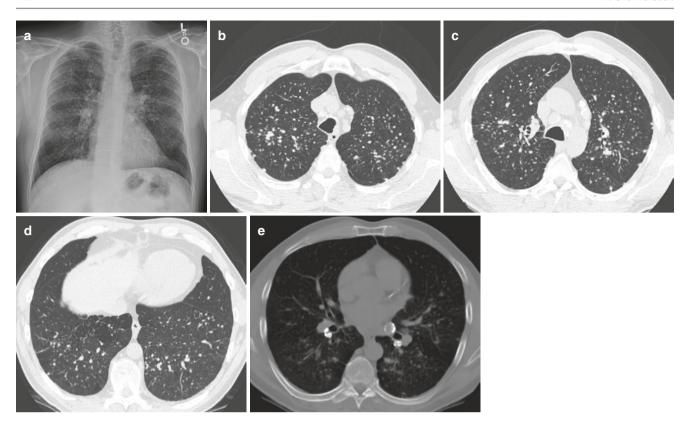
Simple silicosis. (a) Frontal radiograph shows diffuse nodularity in both lungs. (b–e) Axial CT images show upper lung predominant perilymphatic nodules (subpleural and along centrilobular
